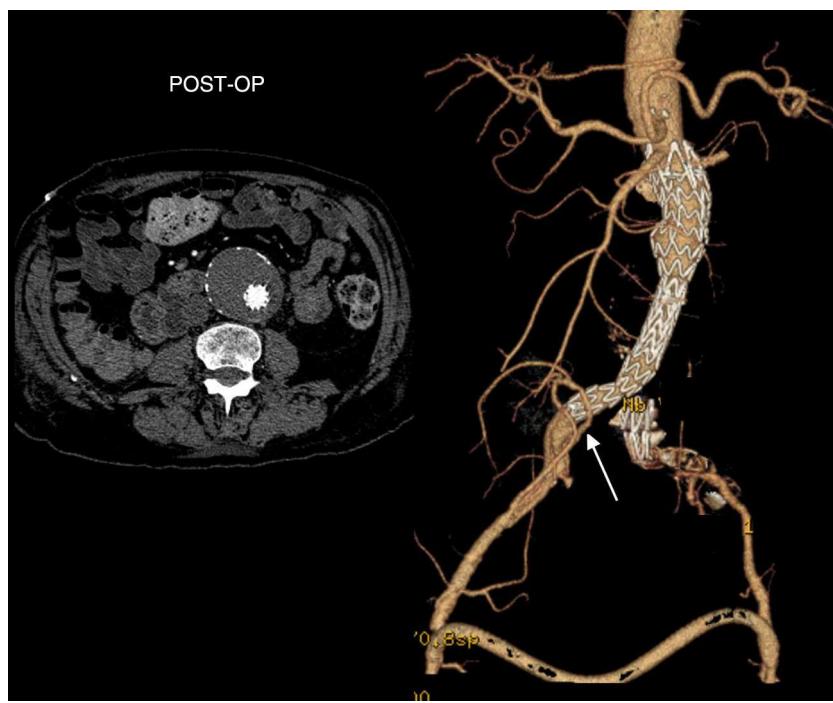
Post-operative CT scan: endovascular successful AAA exclusion, with patent ilio-renal (arrow) and femoral crossover bypasses.
